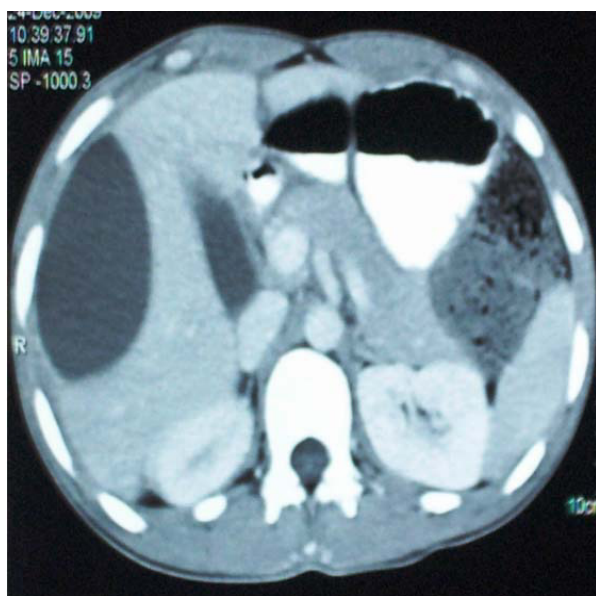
CT image showing a defect in the gallbladder fundus and a localized subcapsular hepatic septate collection.
